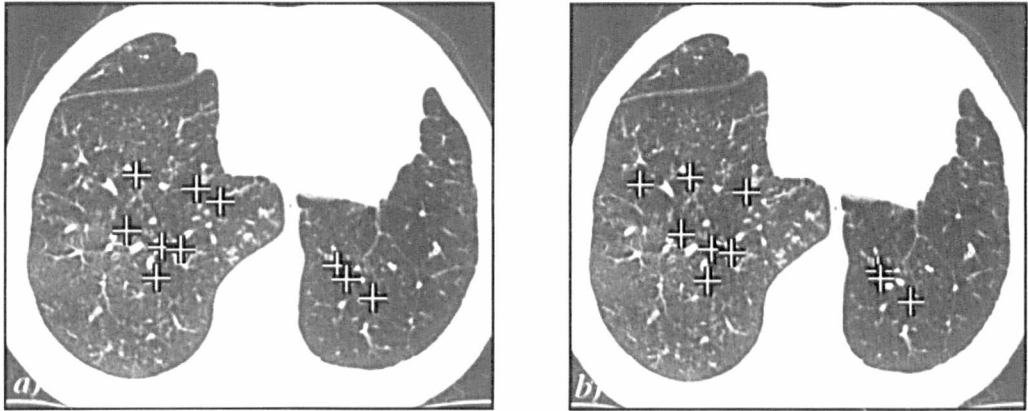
a)* HRCT scan of the lower zone of the lungs. The most significant bronchi, as identified by an experienced radiologist, are marked with a cross. *b)* Bronchi found by the ERS transform on the same image. The automated method matches the results of the human observer in 9 out of 10 instances.
